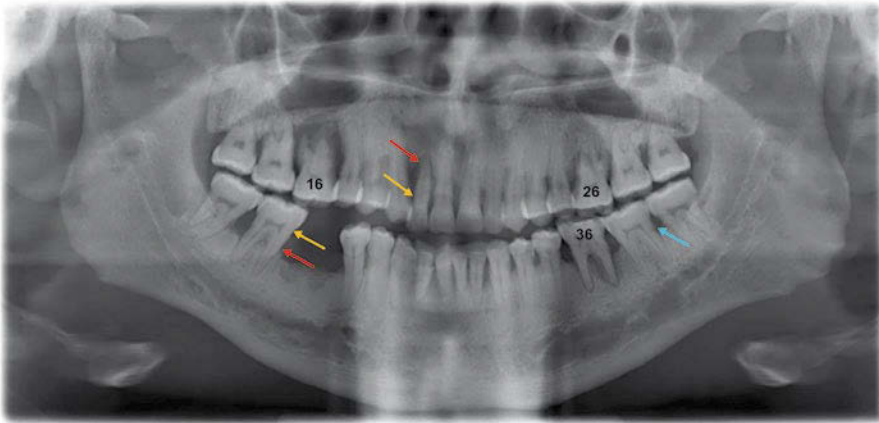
Panoramic radiograph of a 24-year old man with severe generalized aggressive periodontitis. *Yellow arrows* are marking height of healthy alveolar bone, *red arrows* are marking the actual bone level of this patient. The *light blue arrow* is marking concrement, which is a rare finding in aggressive periodontitis. Severe bone loss is present around the first molars (16, 26 and 36–46 is already missing)
